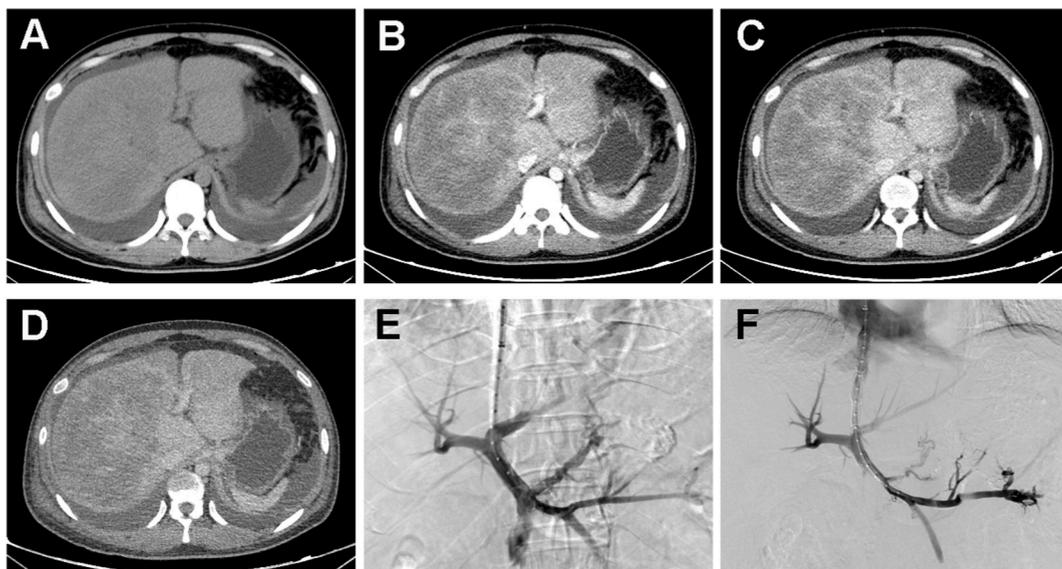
A 55-year-old man diagnosed with HSOS with a history of ingestion of herbs containing PA. A–D Abdominal CT showed ascites, hepatomegaly, and heterogeneous enhancement. A Plain scan; B Arterial phase; C Portal phase; D Venous phase; E Portography before shunt creation; F Portography after shunt creation.
